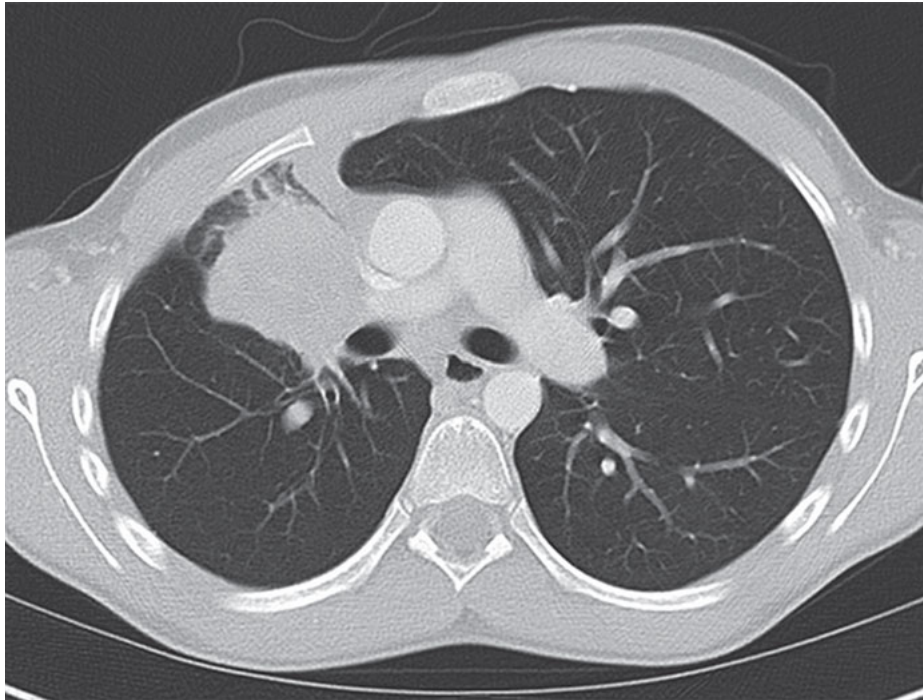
CT scan with contrast of an inflammatory myofibroblastic tumor.
